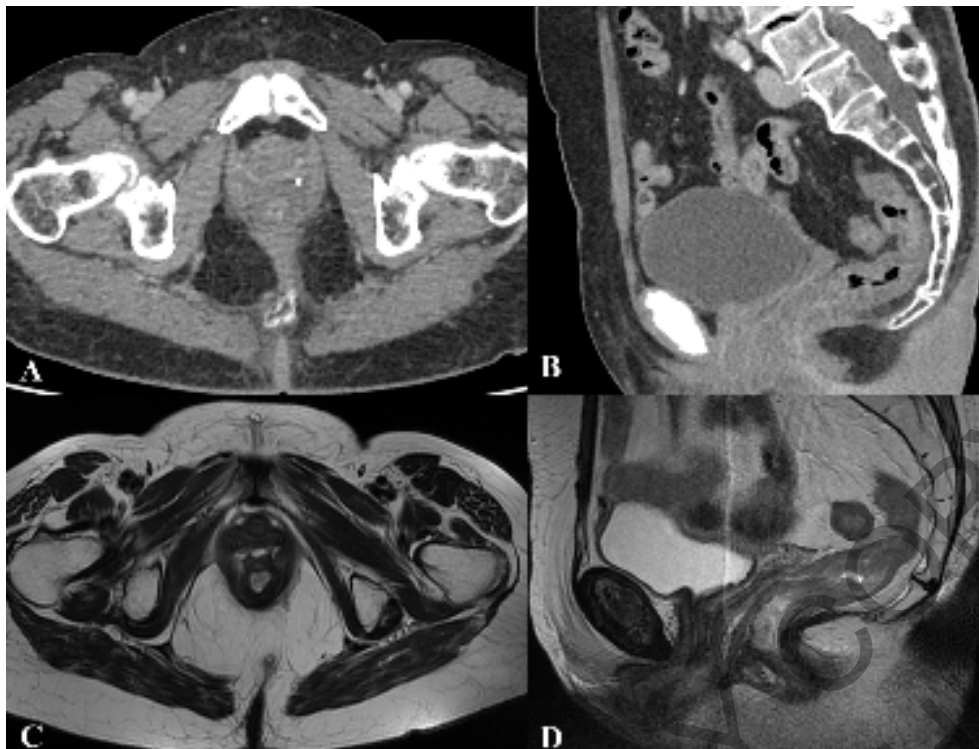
After radiochemiotherapy, axial CT venous phase (A), with sagittal reconstruction (B), axial (C) and sagittal (D) MRI T2-weighted images show no abnormal mass in presence of diffuse hypointensity of anal sphincter, due to fibrosis, and mild thickening of anorectal wall, due to edema.
